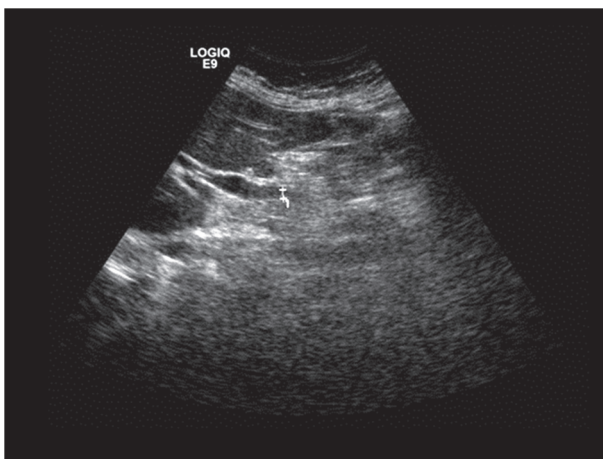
Right upper quadrant ultrasound demonstrating mild proximal dilatation of the common bile duct with smooth tapering of the duct distally. No common bile duct stone is present
